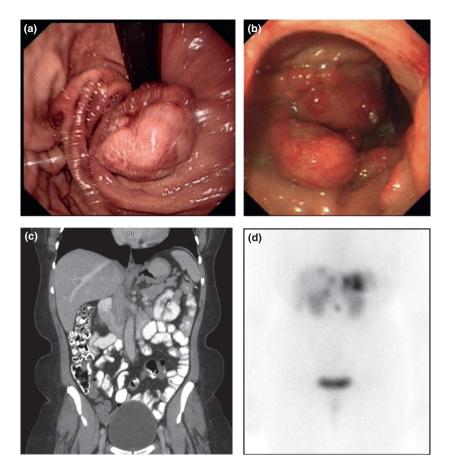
(a) A large type 3 gastric carcinoid viewed on retroflexion in the gastric cardia. (b) A large type 3 gastric carcinoid in the fundus. (c) CT scan of type 3 gastric carcinoid shown in b. (d) Octreoscan of type 3 gastric carcinoid shown in b with uptake in fundus.
